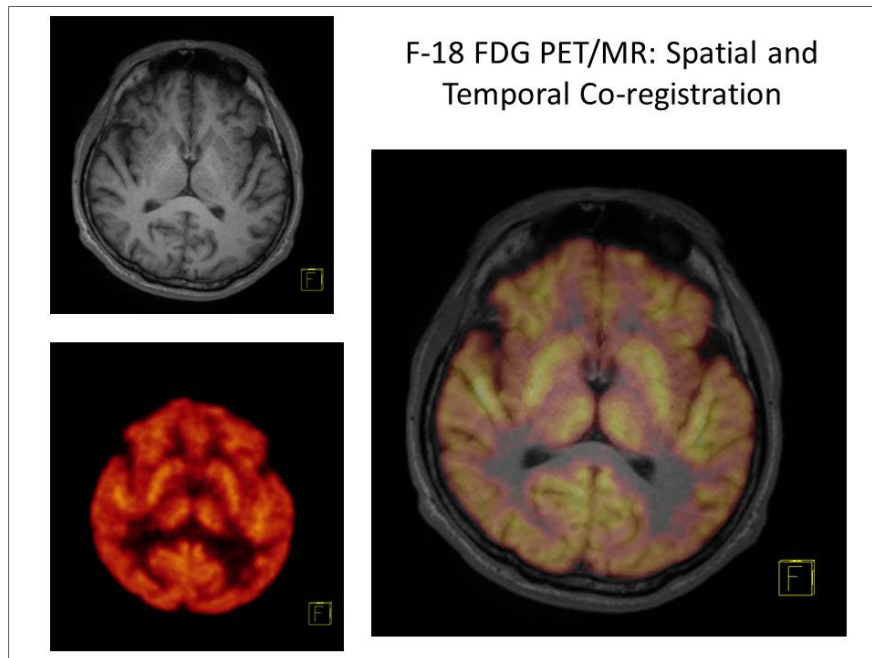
A brain MRI anatomical image (upper left) and a PET glucose metabolism image (lower left) are de facto superimposed in three dimensional space (right image) as the MRI and the PET image were acquired at the same time over the same imaging volume using a hybrid PET/MRI medical imaging system (Biograph mMR, Siemens Healthcare)
